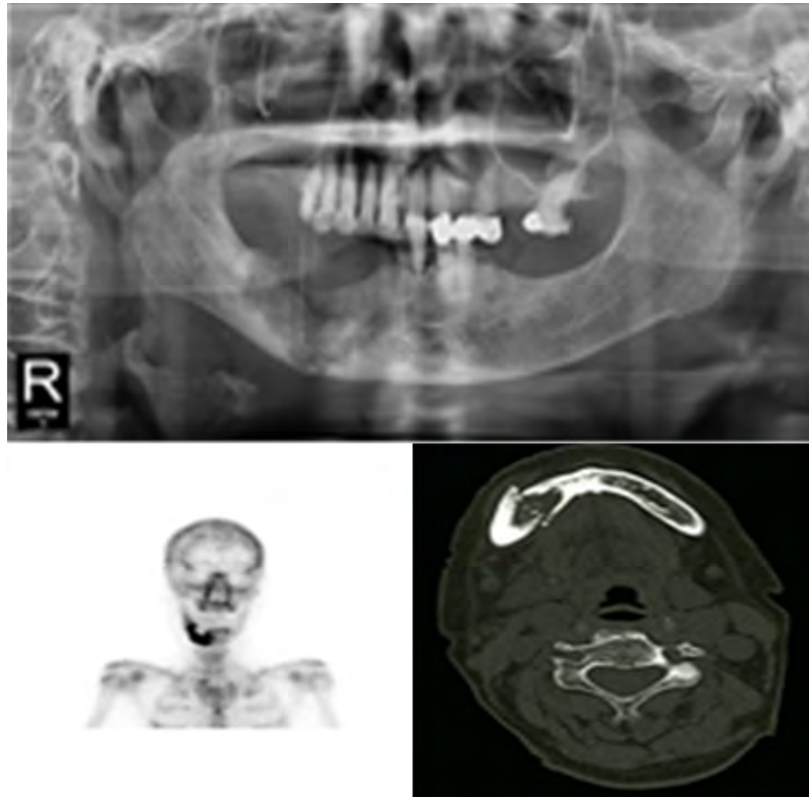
Panorama, CBCT, and bone scan of patient before operation (case 1).
